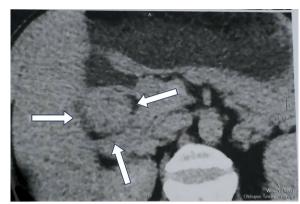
Computed tomography scan revealing the mass in the pyloric region of the stomach. White arrows point at the lesion
